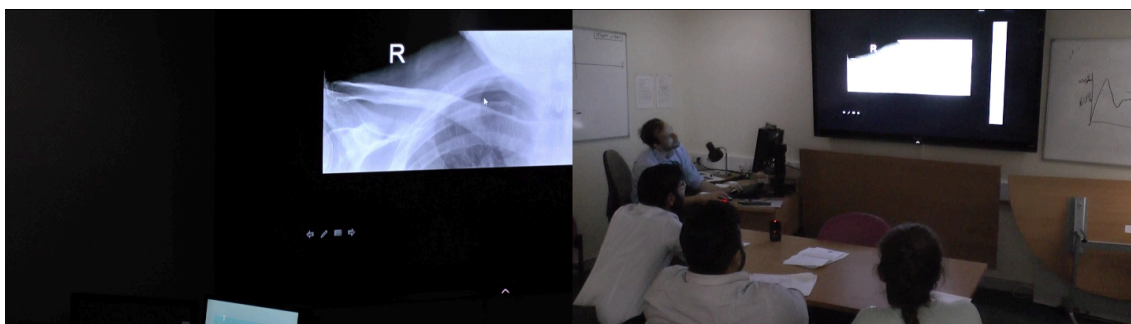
Dr. Delichon presents a magnified or zoomed image of the same radiograph (Fig. 24) to help Amit, Rehan and Riya see the subtle pneumothorax.
